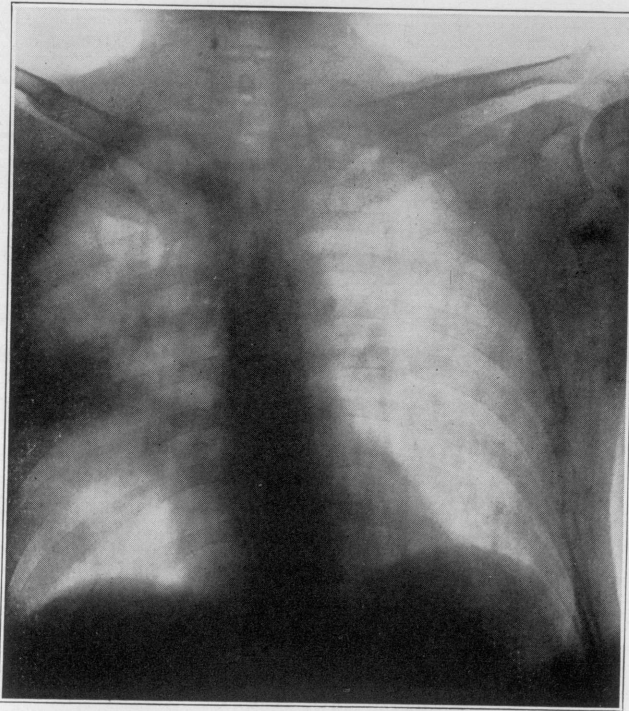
Roentgenogram, taken at end of October, suggesting the diagnosis of an interlobar empyema on the right side, particularly in the light of the clinical history and phenomena.
